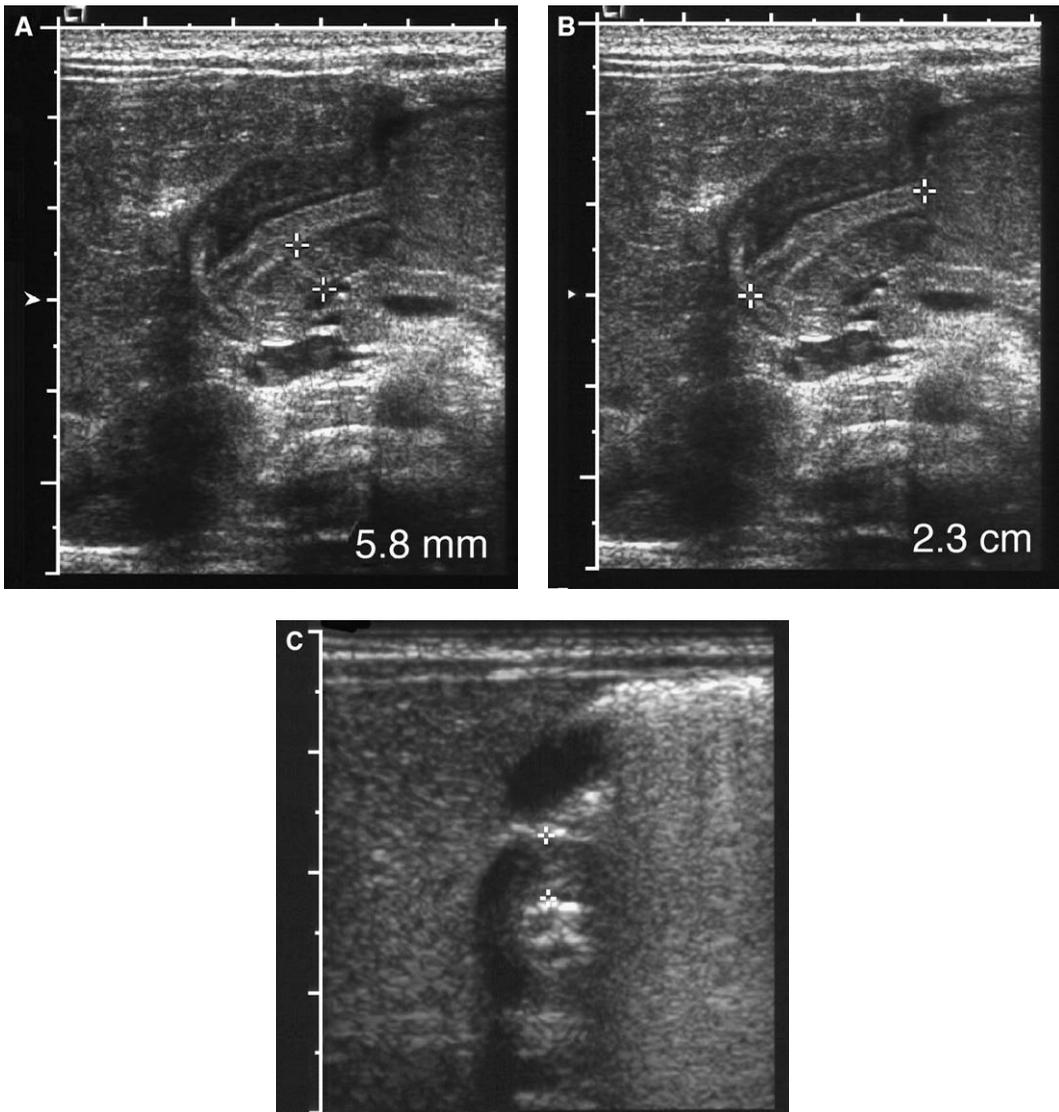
Hypertrophic pyloric stenosis. (A,B) Longitudinal sonographic views demonstrate the hypertrophied pyloric muscle measuring 5.8 mm. The pyloric channel is elongated measuring 23 mm. (C) Cross-sectional view shows the thickened hypoechoic muscle surrounding the echogenic mucosa.
